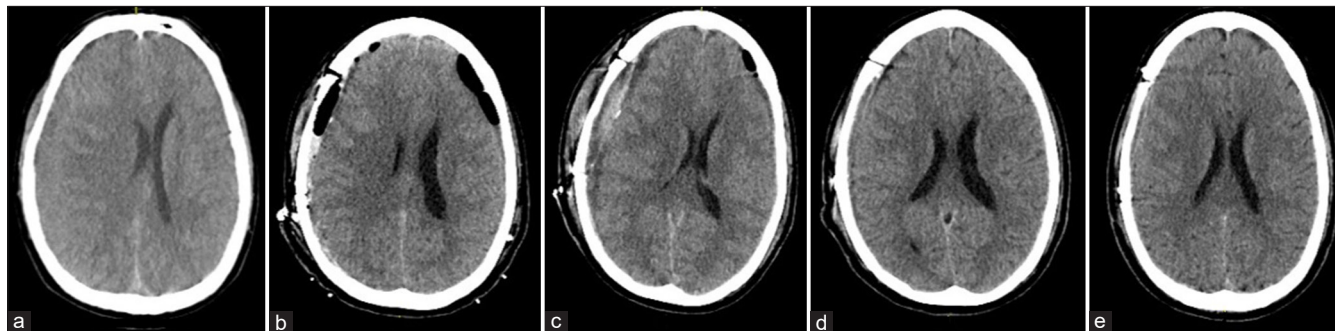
Computed tomography (CT) scans of the brain axial slices. (a) Initial scan showing bilateral subdural haematomas with marked midline shift to the left. (b) Day one postoperative CT scan showing adequate evacuation of the subdural haematomas. (c) Day 7 postoperative CT scan showing recurrent bilateral subdural collections. (d) CT scan 1 week and (e) CT scan 6 weeks after targeted blood patch.
